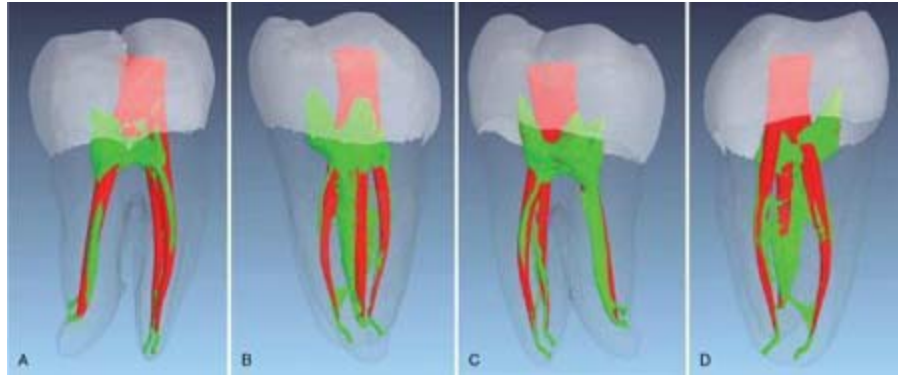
Merged μ CT images of a mandibular first molar demonstrating the root canals pretreatment (*green*) and posttreatment (*red*). A, Buccal view. B, Distal view. C, Lingual view. D, Mesial view.
